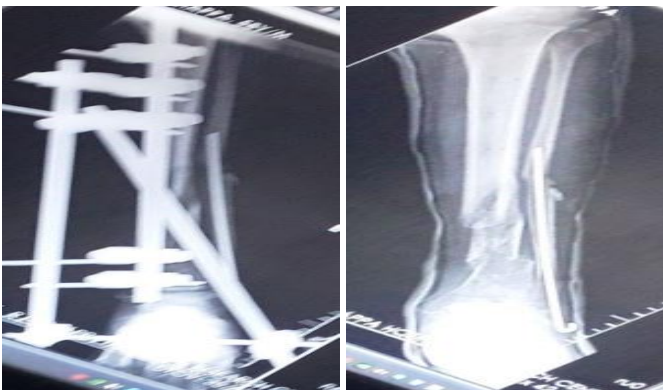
4 month X-ray AP view 5 1/2 month X-ray AP view
